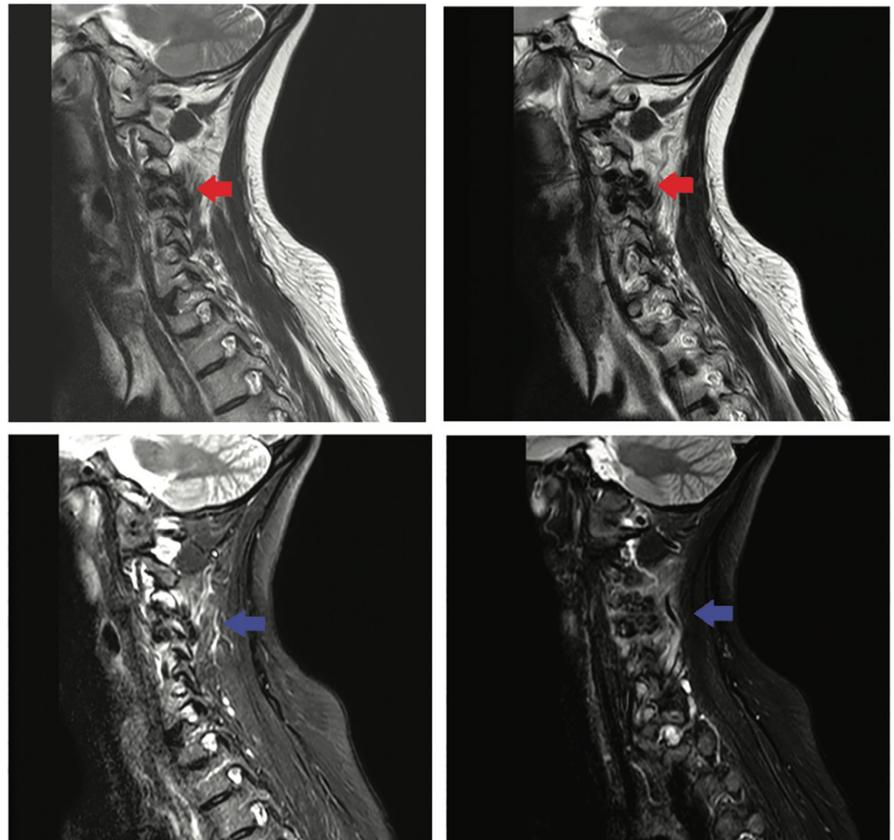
Magnetic resonance imaging (MRI) of the cervical spine. Red arrows indicate the calcinosis lesions on the T2-weighted sequence and blue arrows in the STIR sequence.
